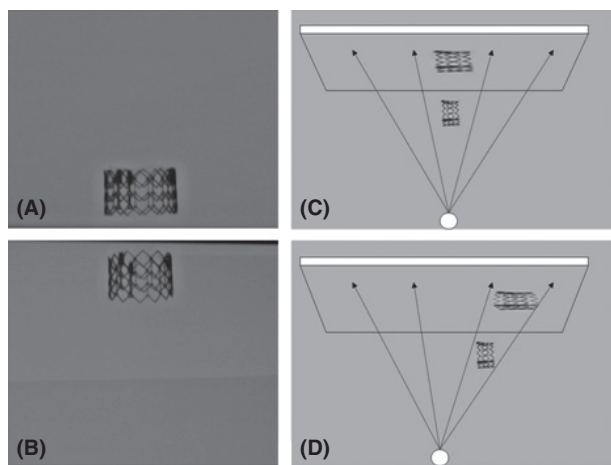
Change in appearance of the trans-catheter aortic valve replacement (TAVR) device as it is moved from the bottom to the top of the image. This figure demonstrates how the TAVR device can change in appearance as it is moved from the bottom of the image to the top. (A and B) In this case, a 29 mm valve in a 32 cm field of view (FOV) and its change from excellent in (A) to satisfactory in (B). (C and D) Describes how the TAVR device changes its appearance on the image due to the divergent nature of the X-ray beam and the resultant distortion.
